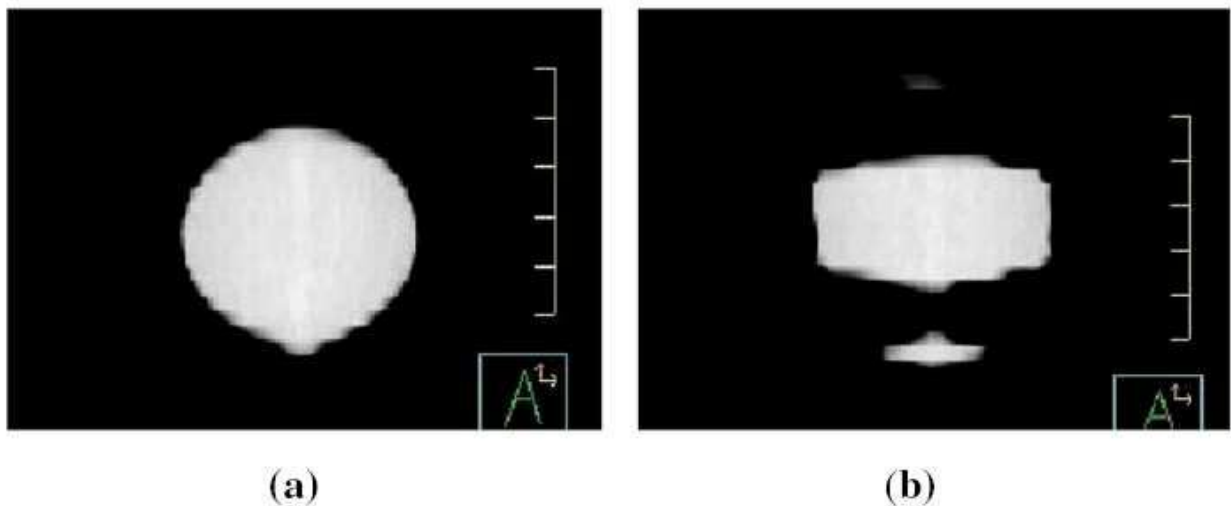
Coronal views of CT scan of a static sphere (a) and a sinusoidally moving sphere (b) (2-cm range of motion and a 4-second period). (Vedam et al 2003)
